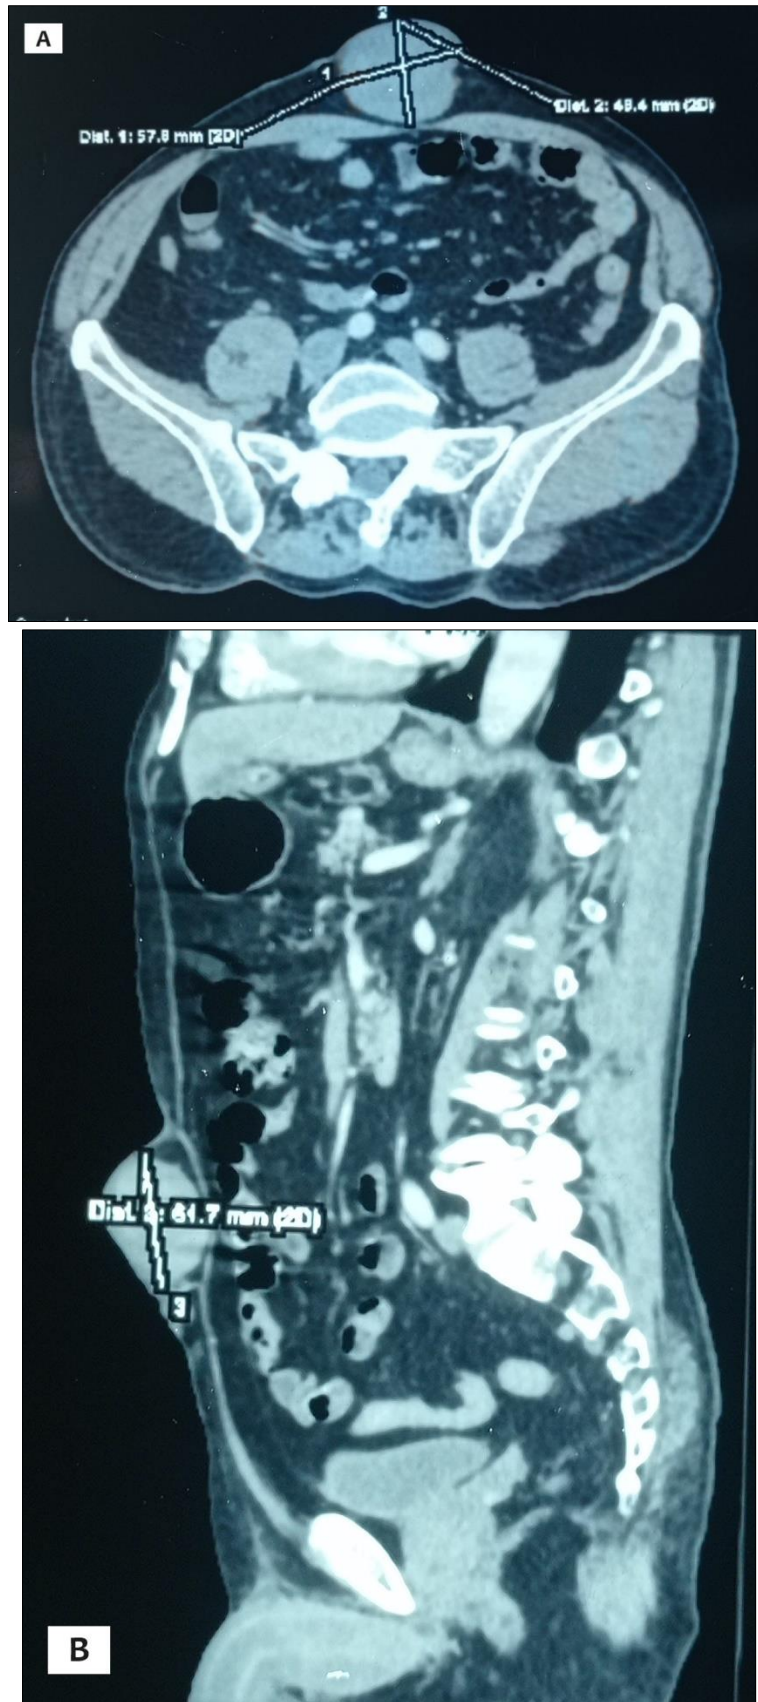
CT axial and sagittal sections passing through the largest mass, measuring 57*48*61 mm, with cutaneous and subcutaneous development without invasion of the aponeurosis of the rectus muscle or the umbilicus
